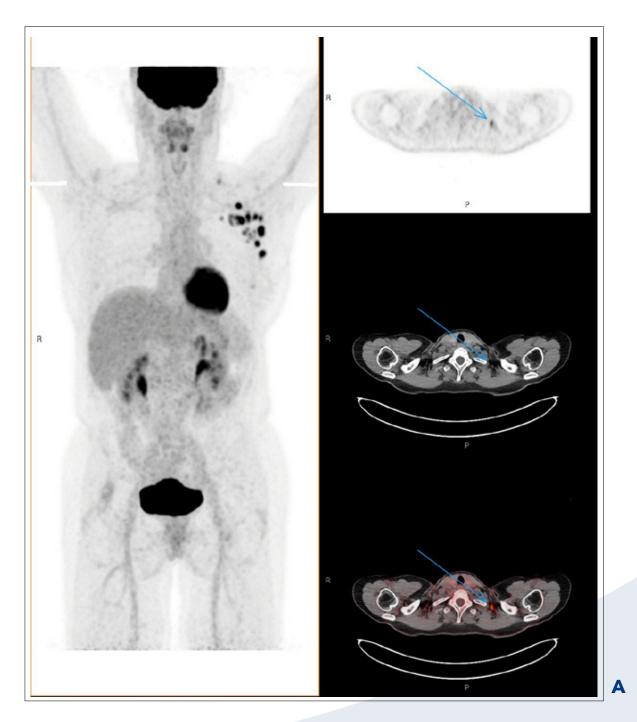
Two patient examples with relevant findings on [¹⁸F]FDG PET/CT affecting tumour staging and treatment A: an FDG-avid supraclavicular lymph node, ipsilateral to the breast tumour and axillary lymph node metastases, resulted in upstaging of the breast cancer from stage IIIA (cT1c N2a Mx) to stage IIIC (cT1c N3c M0) and expansion of the radiation field for adjuvant radiotherapy. B: an FDG-avid, biopsy-proven sacral bone metastasis led to upstaging of the breast cancer from stage IV (M1, oligometastatic). The lesion was included in the radiotherapy treatment. Notably, FDG uptake was also observed in several left axillary lymph nodes, which was not due to metastatic involvement, but attributed to a reactive response following recent administration of a COVID-19 vaccine in the left upper arm.
